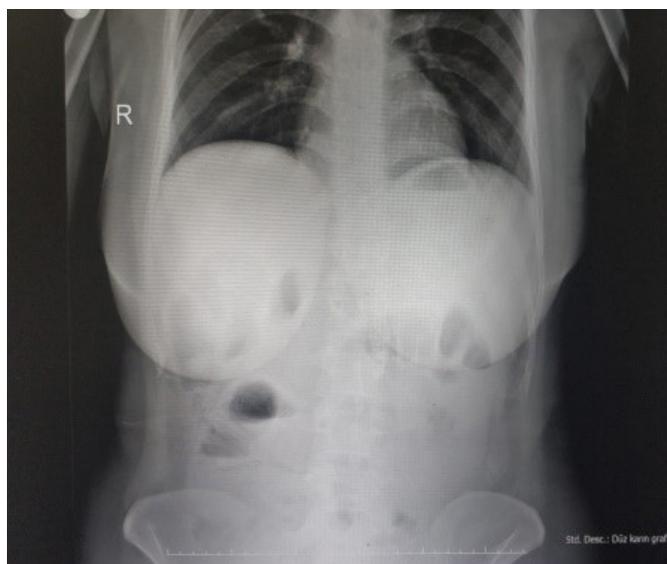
1st day of hospitalization, standing direct abdominal X-ray
